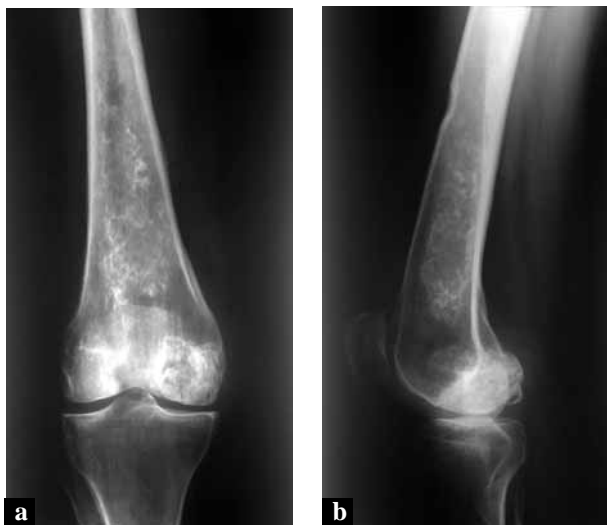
AP and lateral radiographs of knee and distal femur.
